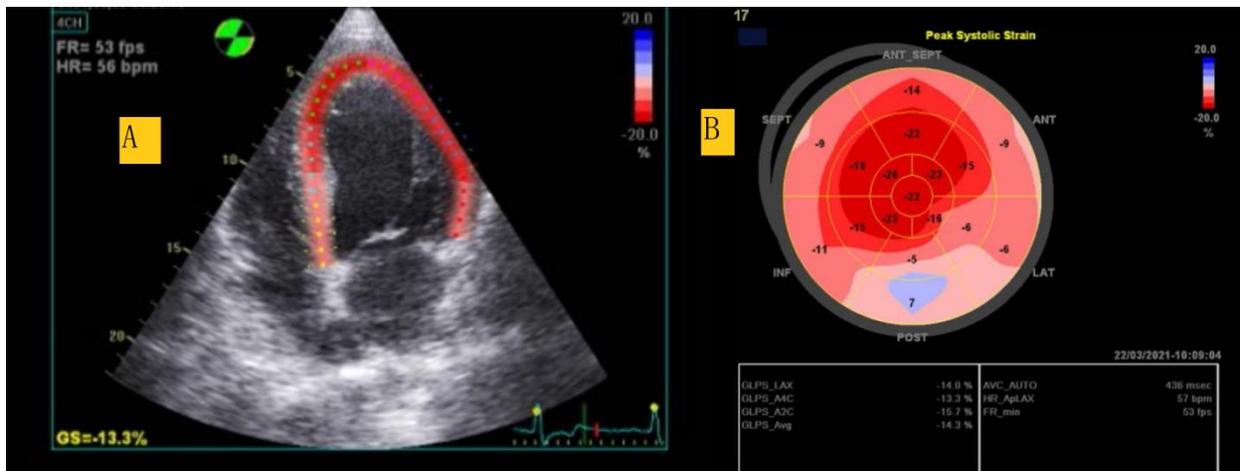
The images depict A) left ventricular global longitudinal strain (apical 4-chamber analysis) and B) bull's eye, showing a reduced overall left ventricular global longitudinal strain value.
